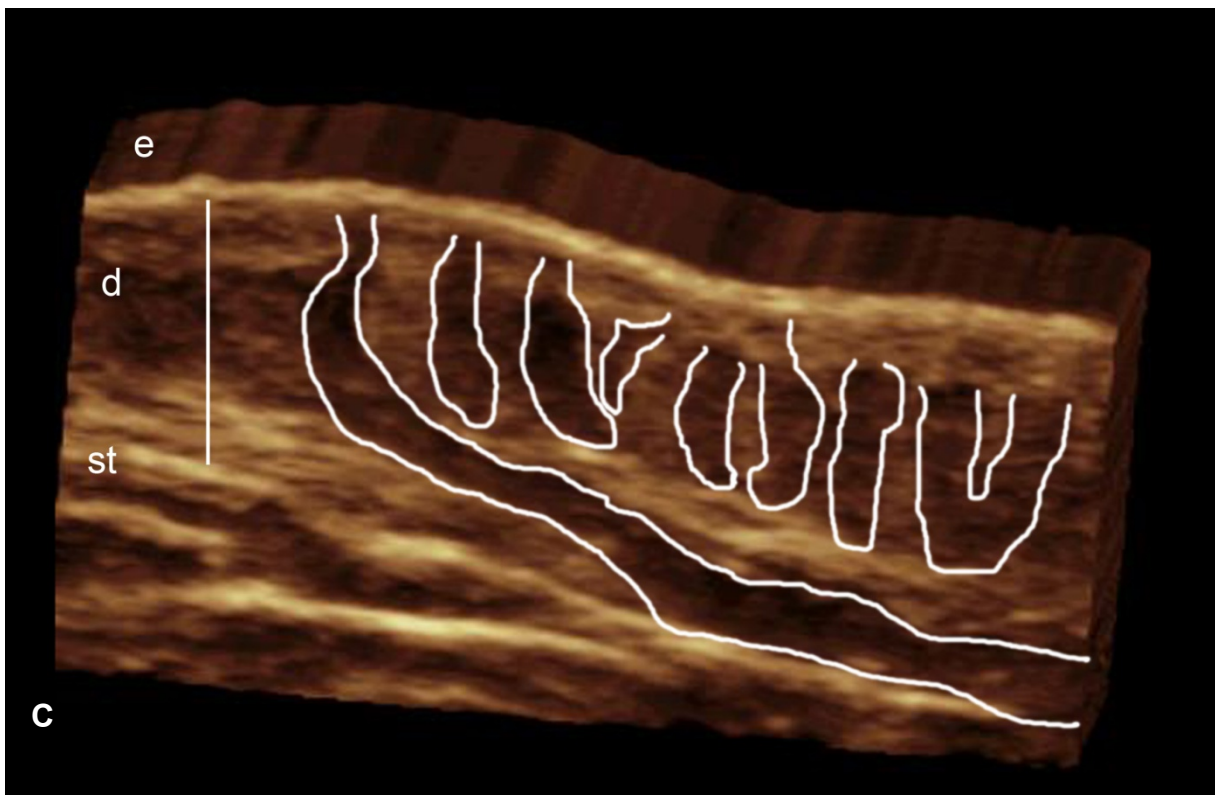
(A-C). Early changes in HS. A. Clinical image of a HS patient classified as Hurley 1. B. and C. 3D ultrasounds demonstrate predominant enlargement of the base of the hair follicles in the deep portion of the dermis. In fig. C the hair follicles have been outlined. Abbreviations: e, epidermis; d, dermis; st, subcutaneous tissue.
